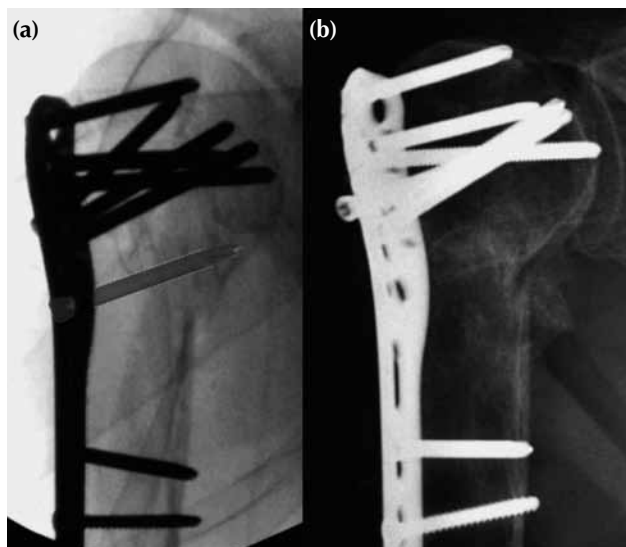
Radiographs showing (a) malreduction of the medial cortex and non-insertion of the inferomedial (kickstand) screw (in grey colour). (b) After 2 months, the humeral head becomes varus with screw backing out and penetrating the articular surface. (Reproduced with permission: Gardner MJ, Weil Y, Barker JU, Kelly BT, Helfet DL, Lorich DG. The importance of medial support in locked plating of proximal humerus fractures. *J Orthop Trauma* 2007;21:185–91.)
